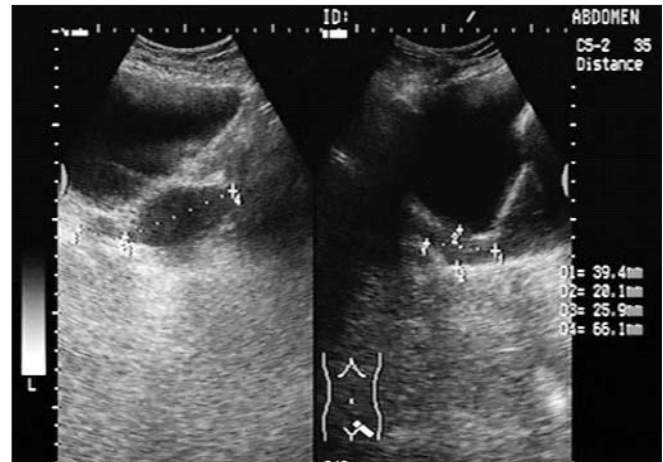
Ultrasound findings: In hypogastrium a 58/22/59 mm hypoechoic mass and in left side a 59/39/41 mm hypoechoic mass, possible ovarian cyst
